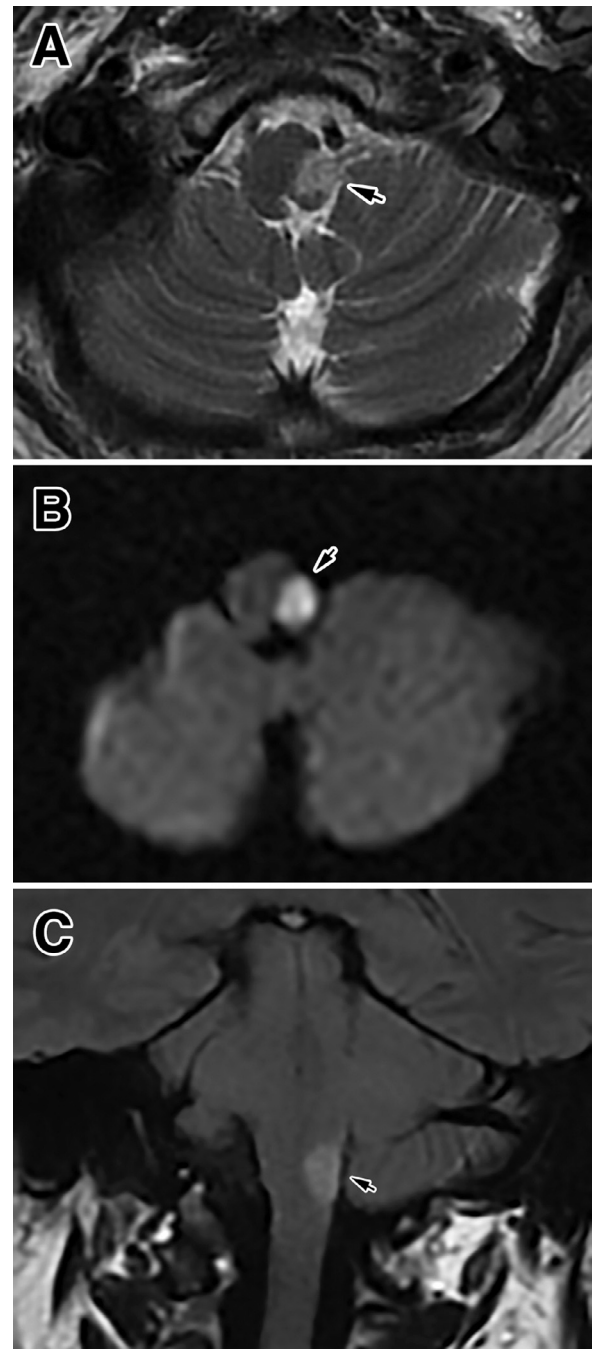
A left large complete lateral infarction (arrows) of the inferior and middle medulla in the axial T2-weighted (A) and DWI images (B), as well as in a coronal FLAIR image (C).
